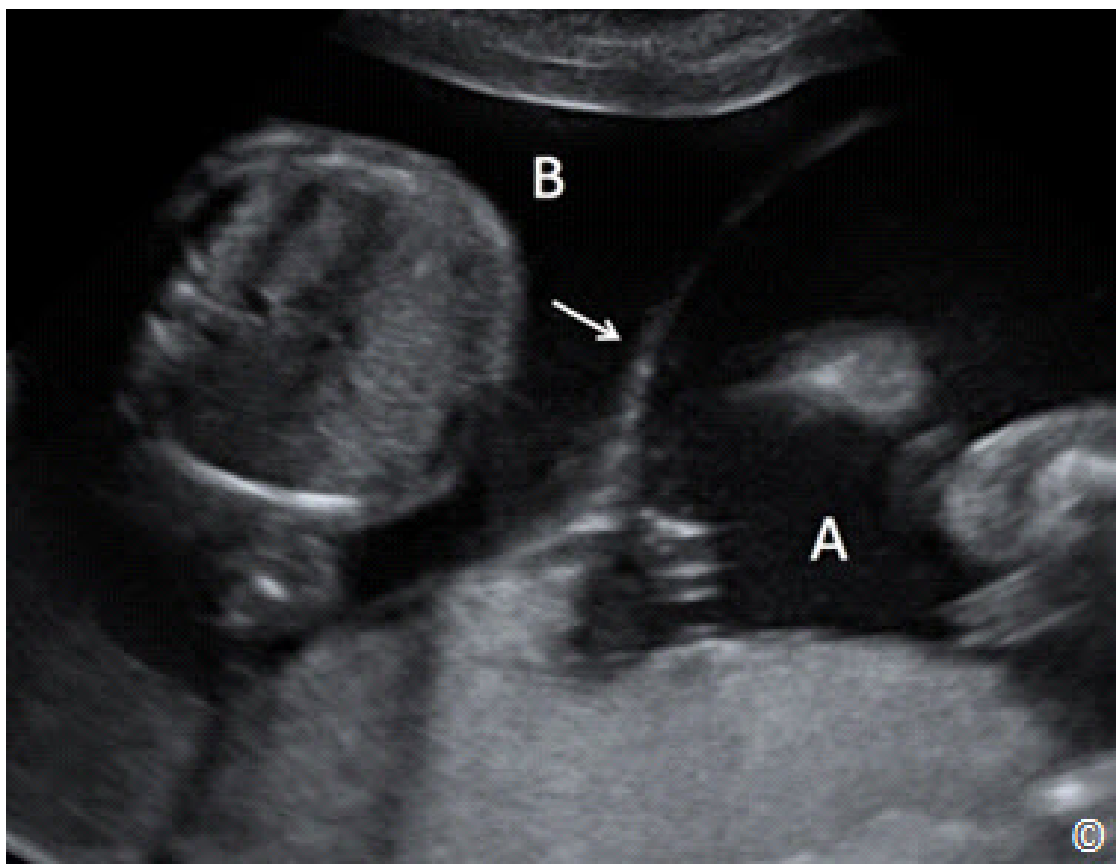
Transabdominal ultrasound of a twin pregnancy showing a thick dividing membrane (arrow) confirming the presence of twins. A and B denote the locations of gestational sacs for twin A and twin B respectively.
